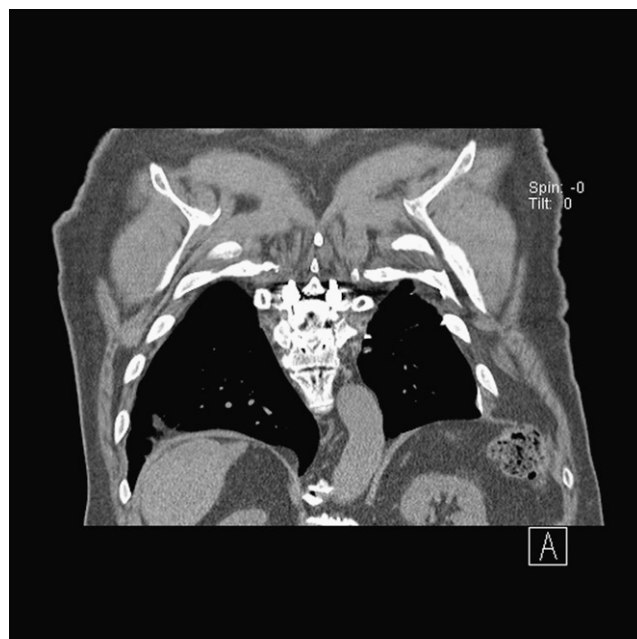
Coronal view computed tomography scan of the chest demonstrating left-sided chest wall deformity and elevation of left hemidiaphragm.
